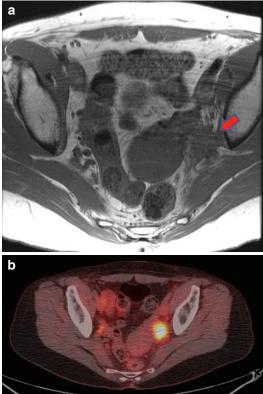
(a) Magnetic resonance imaging shows recurrent carcinoma within left obturator space (*red arrow*). (b) The same area is shown to be fluoro-deoxy-glucose avid on positron emission tomography (Copyright held by, and used with permission of, George J. Chang, M.D)
